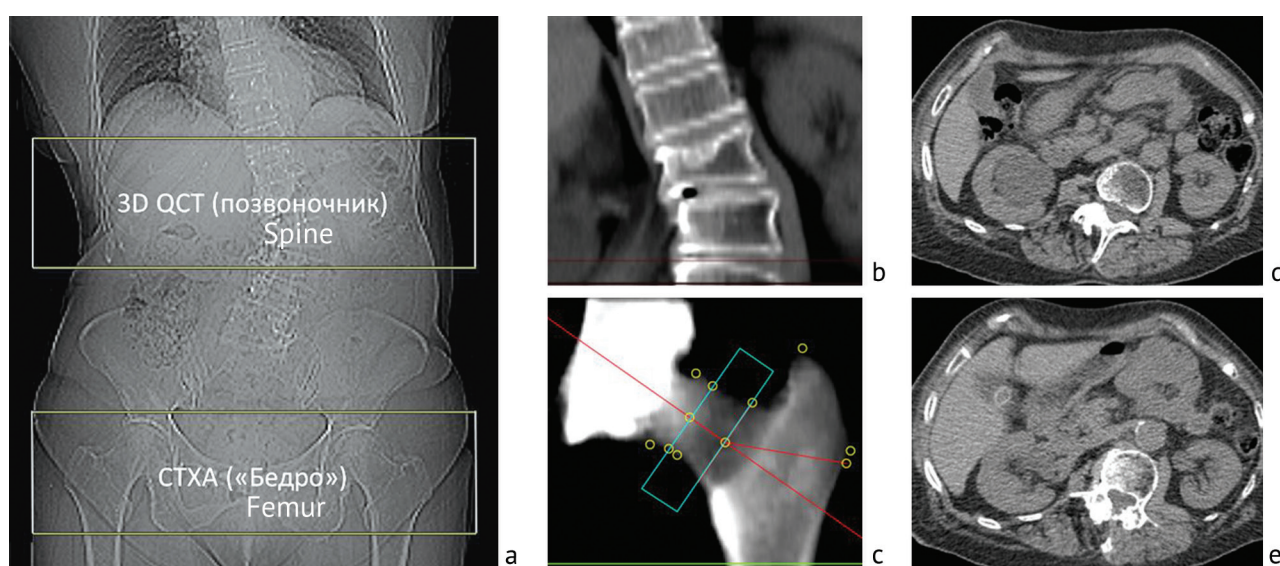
CT images for QCT scan of a 80-year-old patient K. with concomitant pathologies showing (a) marking of the scanning area; (b) scan of the spine, coronal reconstruction demonstrating severe scoliosis, compression fracture of L1; (c) 3D reconstruction of the proximal femur with marks for measuring the BMD of the femoral neck and "the whole femur"; concomitant pathology of (d) cyst in the sinus of the right kidney and (e) concretions in the gall bladder
